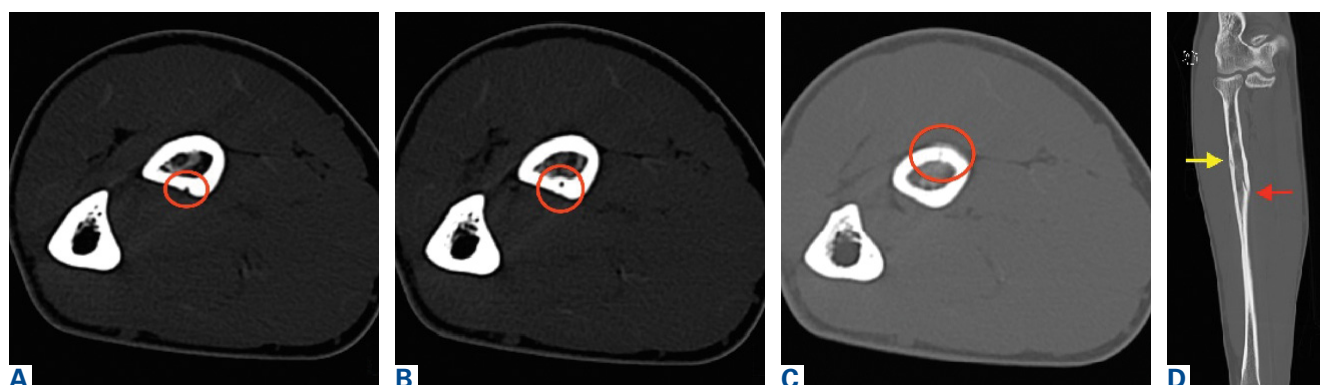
Axial computed tomography shows nutrient vessel and lesion through the cortex of the radius: (A) nutrient vessel enters the radius at the 6 o'clock position, (B) nutrient vessel within the cortical bone at the 6 o'clock position, and (C) stress fracture with periostitis at the 12 o'clock position. (D) Coronal computed tomography shows the cortical fracture (yellow arrow) and the nutrient vessel (red arrow).
